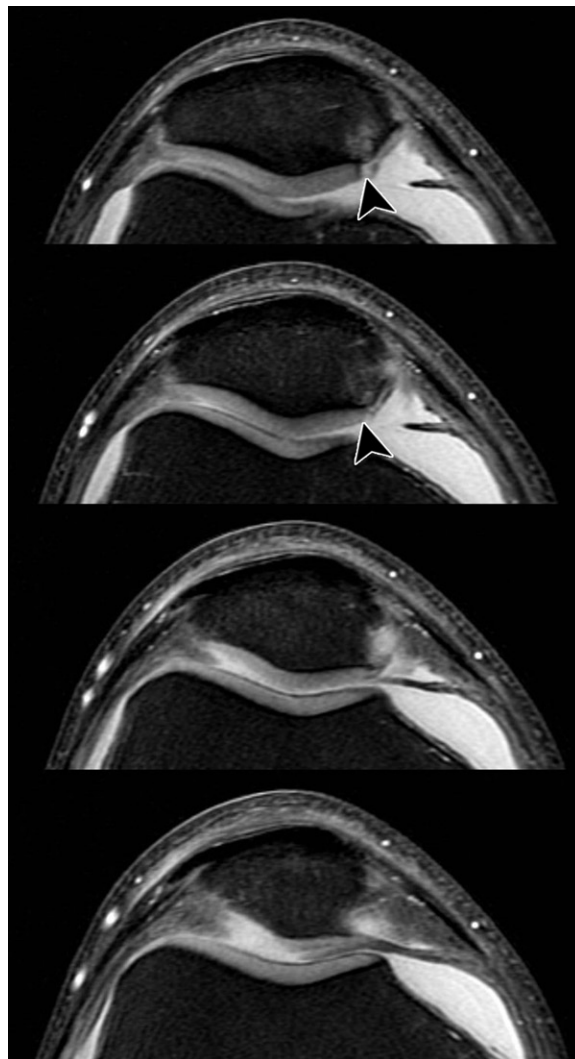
Medial patellar plica causing chondral fissuring at the medial patellar facet. Sequential axial PD-weighted fat-suppressed MR images of the right knee show a prominent medial plica invaginating into the patellofemoral compartment on the more caudal sections. There is fissuring of the cartilage (arrowheads) at the medial patellar facet adjacent to the plica.
